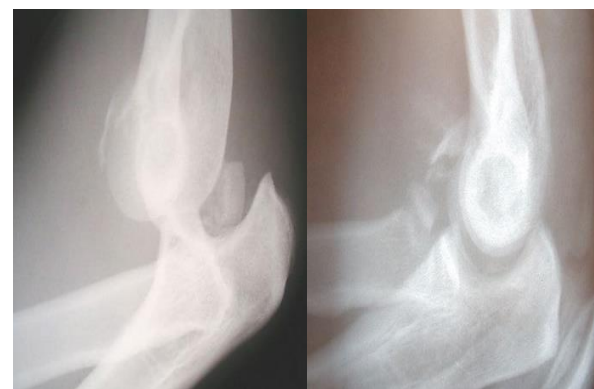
Lateral radiographs of a terrible triad injury showing coronoid and radial head fractures before and after a closed reduction in the emergency department
